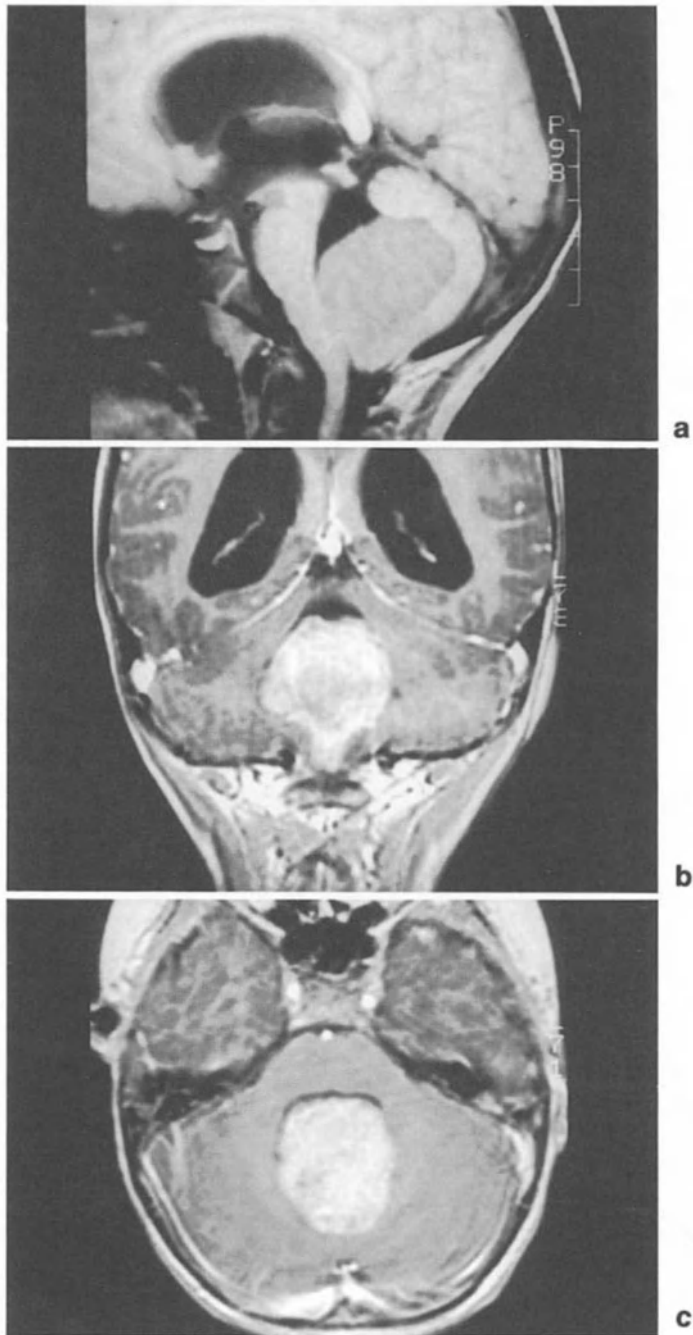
MRI of a medulloblastoma. a) Sagittal cut of the T1 weighted sequence, b) frontal cut of the T1 weighted sequence with gadolinium, c) axial cut of the T1 weighted sequence with gadolinium
